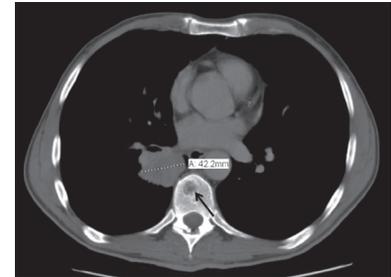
Computed tomography scan showing a 4.2-cm mass in the superior segment of the right lower lobe, identified as the primary lesion. This image also shows a 1.3-cm lytic lesion in a vertebral body (indicated by the black arrow) with extensive neighboring lymphadenopathy.
